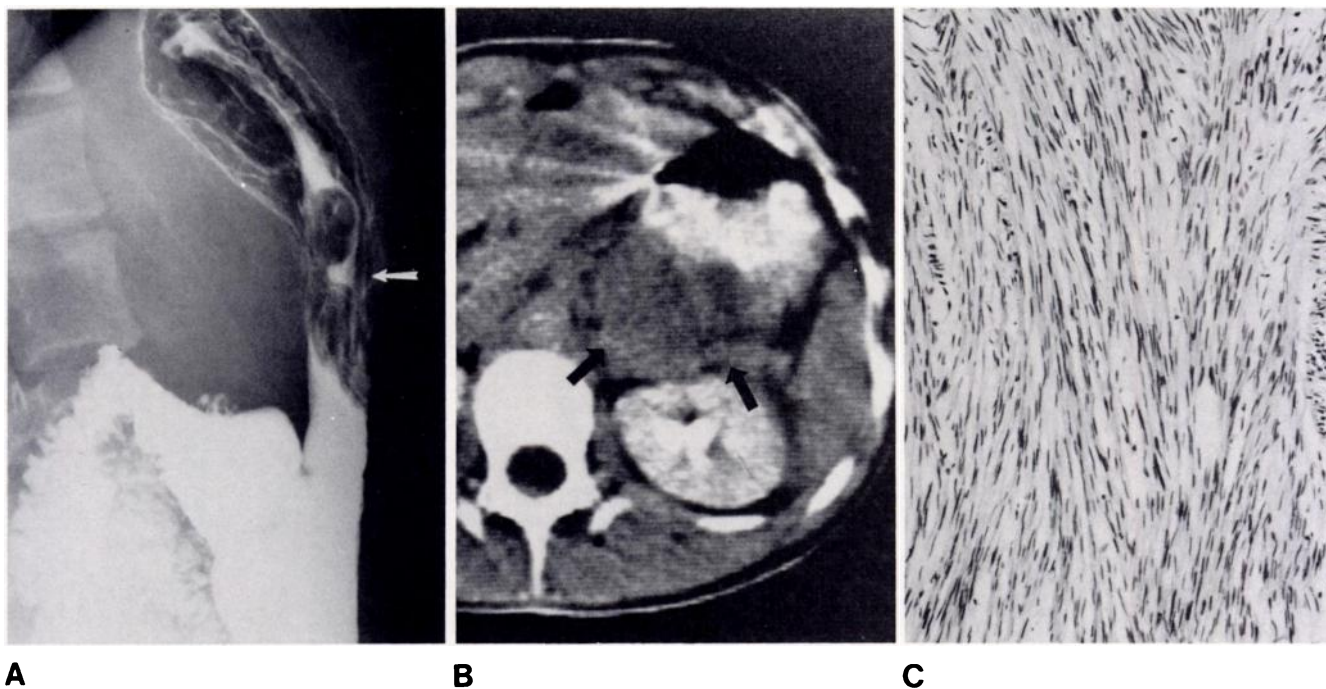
A, Lateral film of stomach. Large, ulcerated gastric mass (arrow). Extrinsic mass effect also present. B, CT of upper abdomen. Large exogastric
